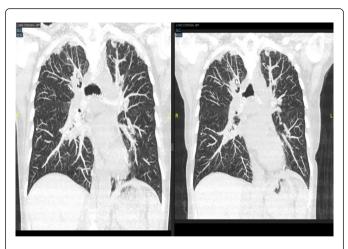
Computed tomography scan of thorax, coronal view; computed tomography (CT) scan of the thorax demonstrating increased apical nodularity over prior studies.
